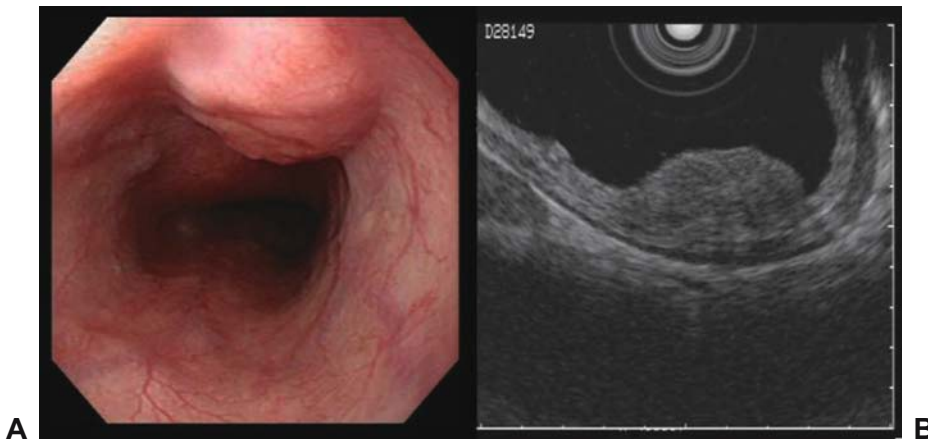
Endoscopic ultrasonography (EUS) pictures of esophageal carcinoma limited to the submucosal layer obtained by ultrasound probe with a 30MHz transducer (B)
